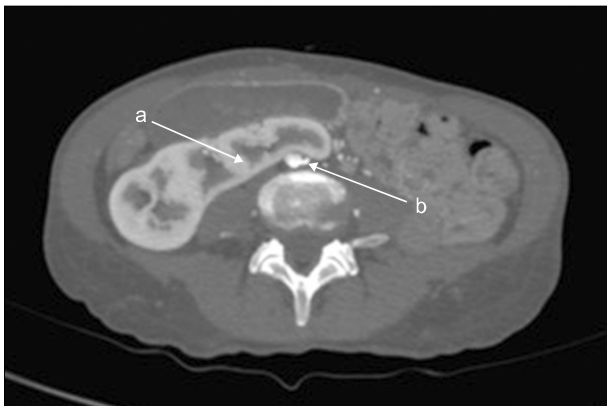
Axial computed tomography depicting (a) crossing renal ectopic tissue and (b) severe occlusive aortic bifurcation disease.
